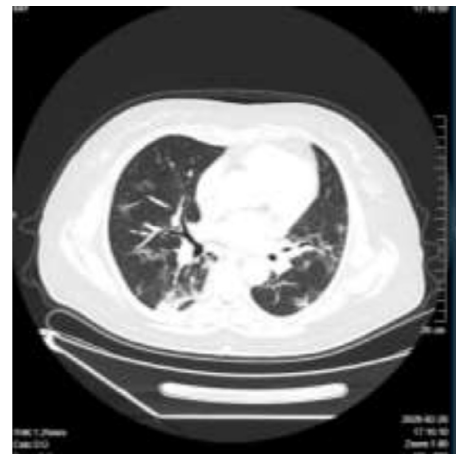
Lung CT image when the patient was discharge.
